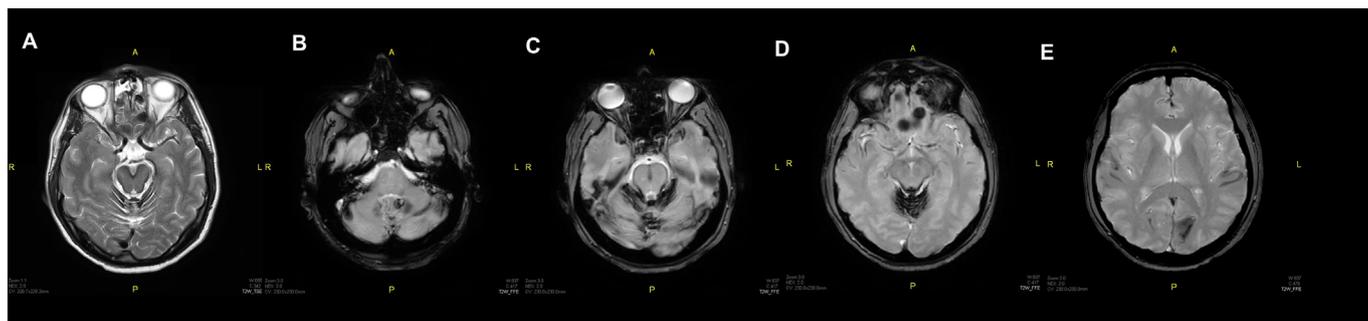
Brain MRI on transversal slices, T2-weighted (A) and echo-gradient (B-E). Hemosiderin hypointensity is evidenced peripherally in midbrain (A). Also hemosiderin is found in the surfaces of cerebellum, pons, midbrain and temporal and occipital sulcus (B-E).
